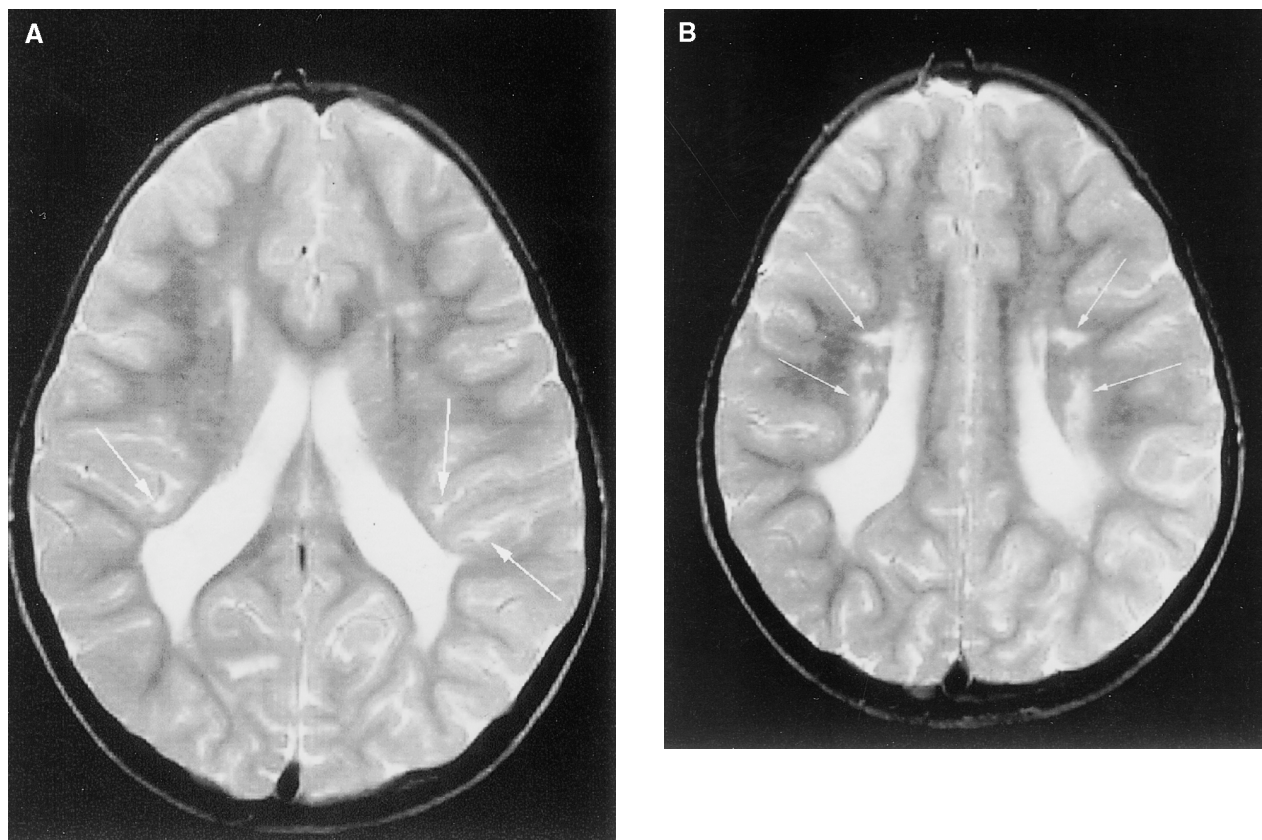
This MRI is from a 4 1/2-year-old girl who was born at gestational age of 33 weeks and had visual impairment but no spastic diplegia. (T2-weighted images). *A:* Note irregular dilatation of the posterior aspects of the lateral ventricles caused by almost complete loss of periventricular white matter. Cortex deep in the Sylvian fissure about directly onto the ventricular wall. Also note the dilatation of the deep portion of the Sylvian fissures bilaterally (arrows). *B:* Note in this image, obtained further cranially than *A*, that the abnormally increased signal in remaining white matter in centrum semiovale (arrows). These findings are consistent with moderate PVL located primarily posteriorly. (Courtesy of Dr Olof Flodmark.)
